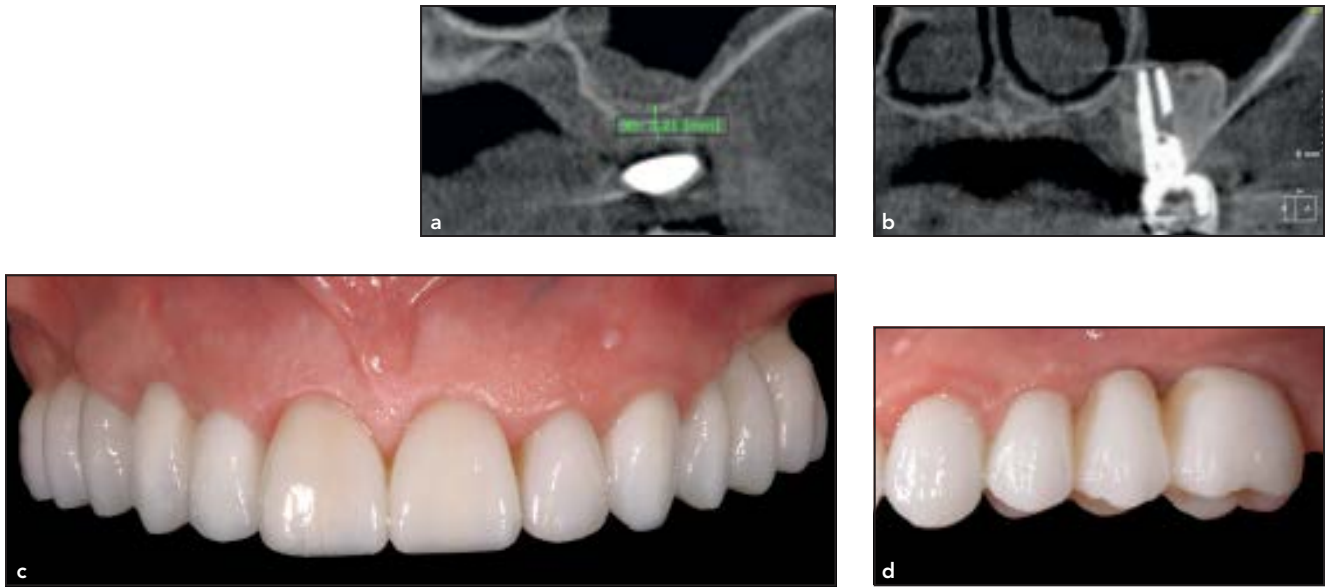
Sequence of a clinical case. (a) Planning. (b) Implant placement. (c, d) Clinical 1-year follow-up. (e) Radiographic 1-year follow-up.
